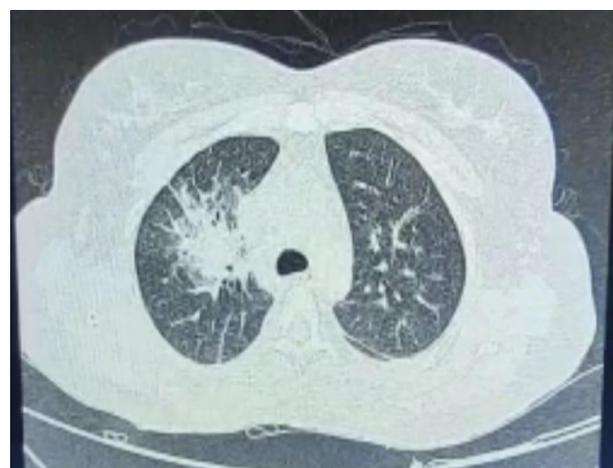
CT thorax showing multiple parenchymal fibrotic and atelectatic bands noted
